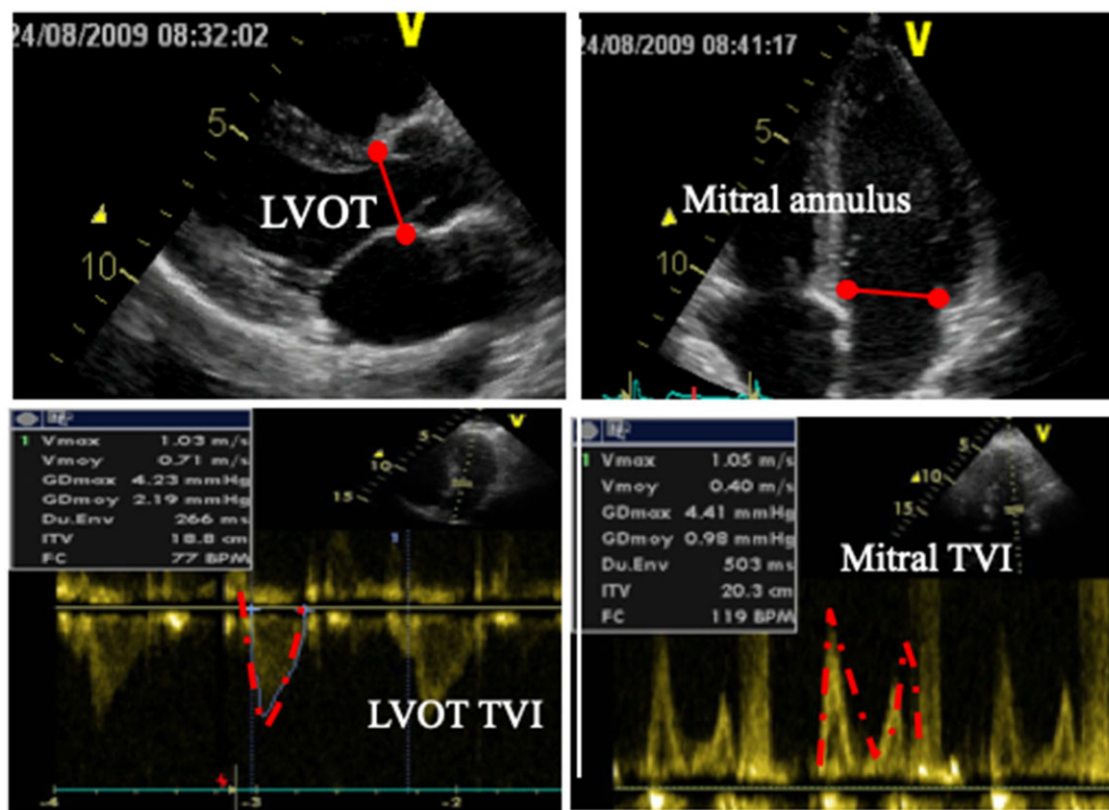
The quantitative assessment of MR severity by the Doppler volumetric method requires the measurement of the left ventricular outflow tract diameter (LVOT), the mitral annulus diameter and of two pulse wave velocity profiles (outflow tract and mitral inflow velocities). TVI, time-velocity integral.
